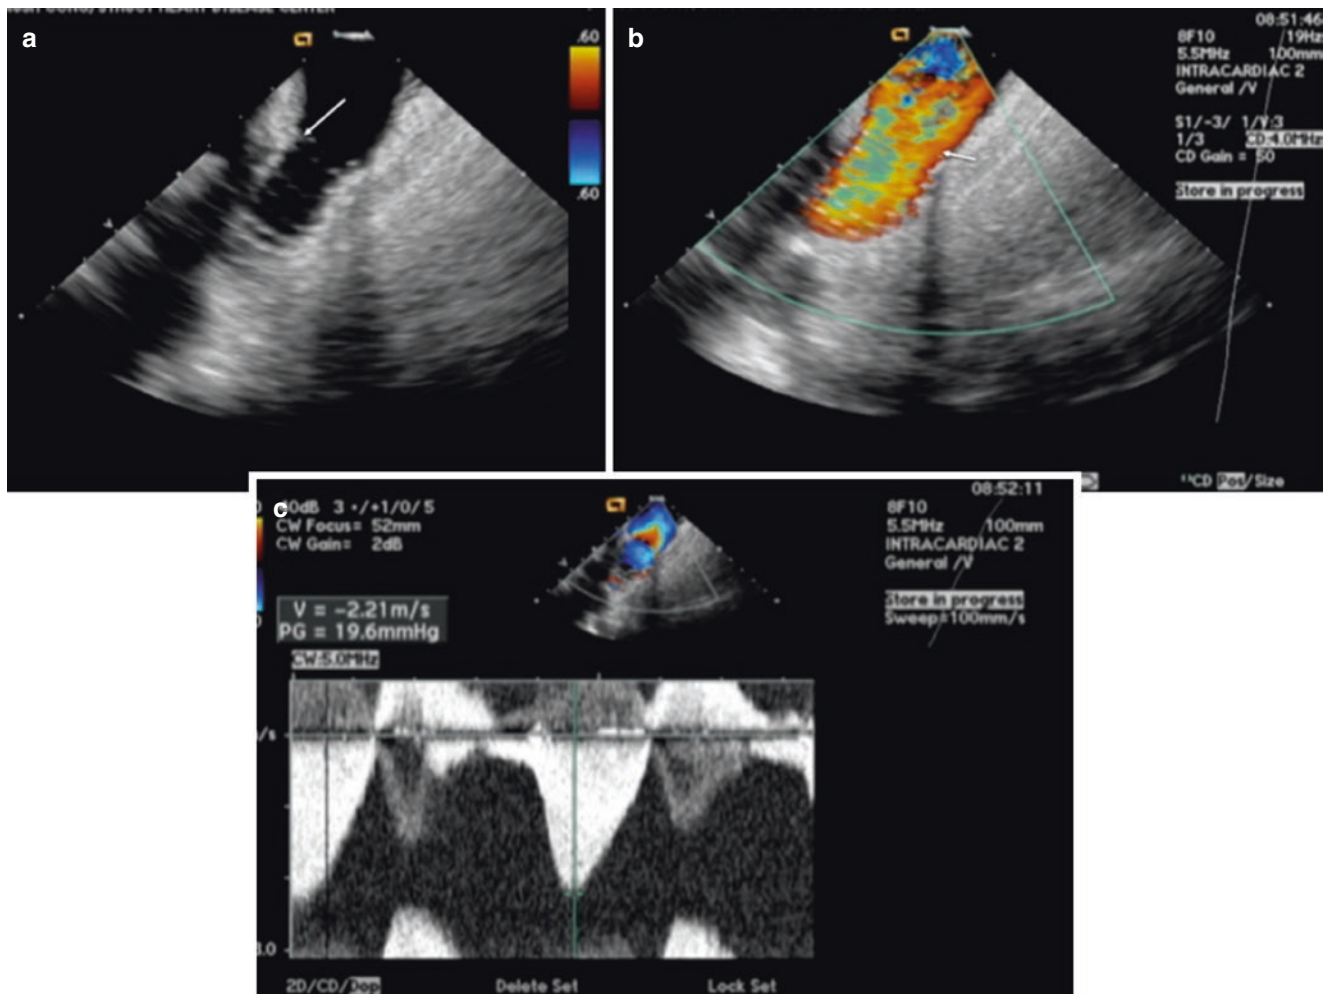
Intracardiac echocardiographic (ICE) images in a patient with dysfunctional homograft who already had a stent implanted in the homograft as a landing zone pre-valve (a, b, c) and post-valve (d, e, f) implantation. (a, b) Views from the right ventricular outflow tract without and with color Doppler showing the stent (arrow) and free regurgitation (arrow). (c) Continuous wave Doppler in the right ventricular
